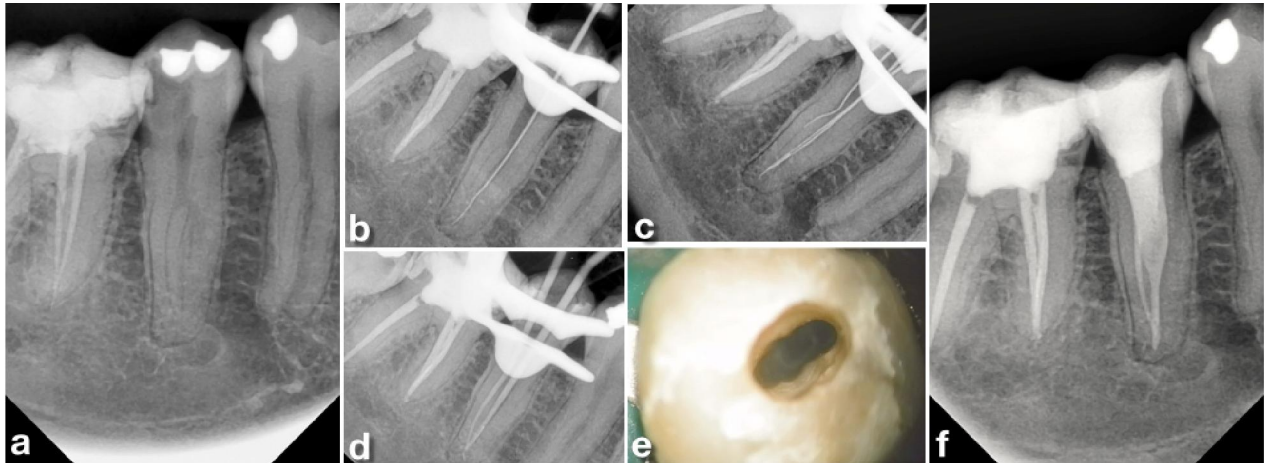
Case 4: a, preoperative radiograph. b, c, working length radiograph. d, master cone radiograph. e, Access cavity view. F. Postoperative radiograph.
